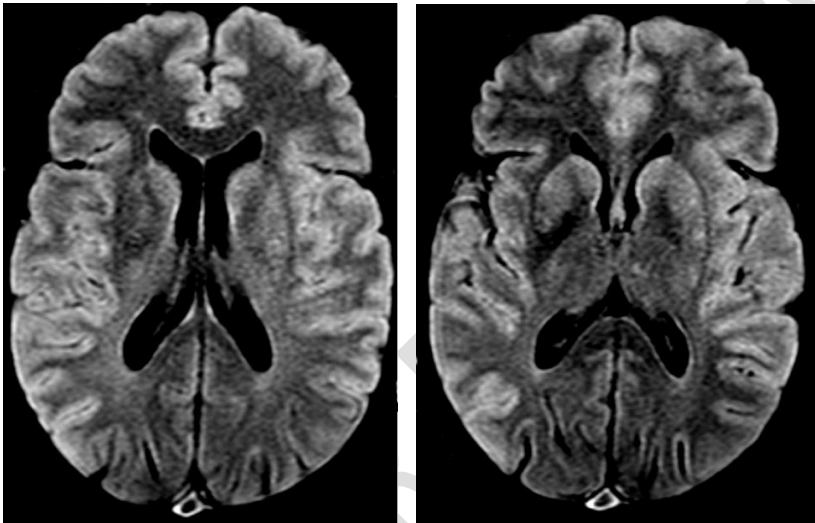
Brain magnetic resonance imaging in FLAIR axial sequence, with generalized and bilateral hyperintensity in the vascular territory of the internal carotid artery.
